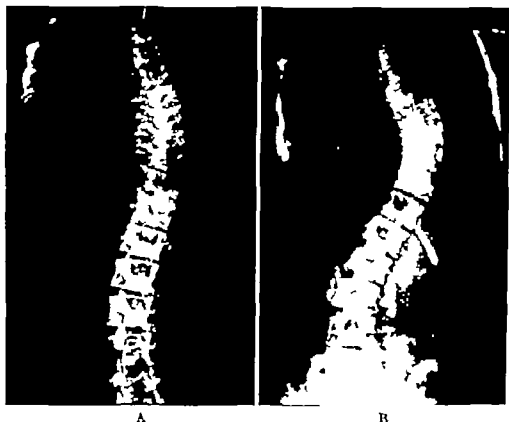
Roentgenograms of scoliotic spine. A, Mild scoliosis. B, Same spine five years later, severe scoliosis.
